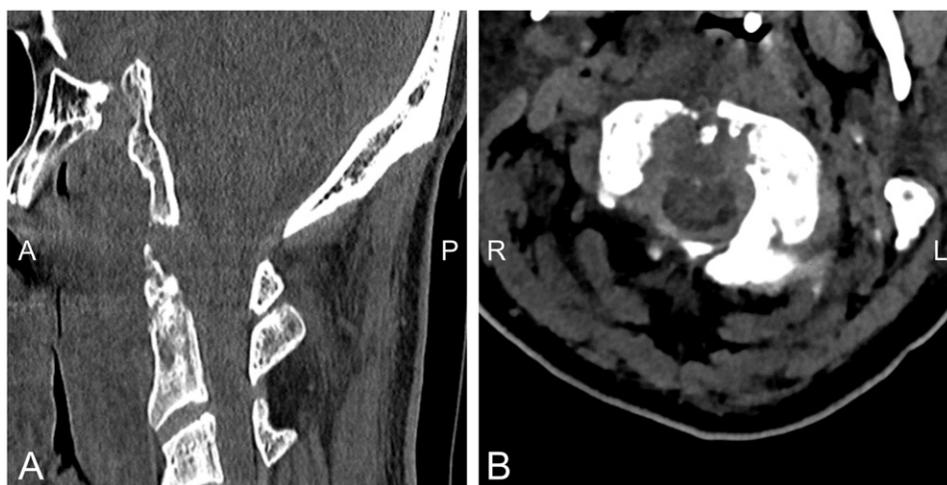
6-Week follow-up CT demonstrates resolution of both lesion and cervical cord indentation. A) Sagittal view demonstrates resolution of the abscess and reduction of phlegmon size in the anterior epidural space of the C1–C2 vertebrae. Cervical cord indentation is resolved and CSF is present throughout the cervical spinal canal anteriorly and posteriorly. B) Axial view demonstrates absence of cervical cord indentation at the C1 vertebra. A ring of CSF encircles the cord.
